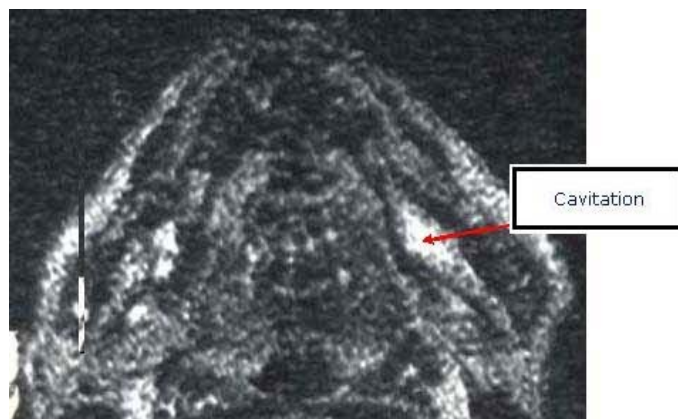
MRI STIR image. The cavitation is the larger white area on the right side of the picture.
